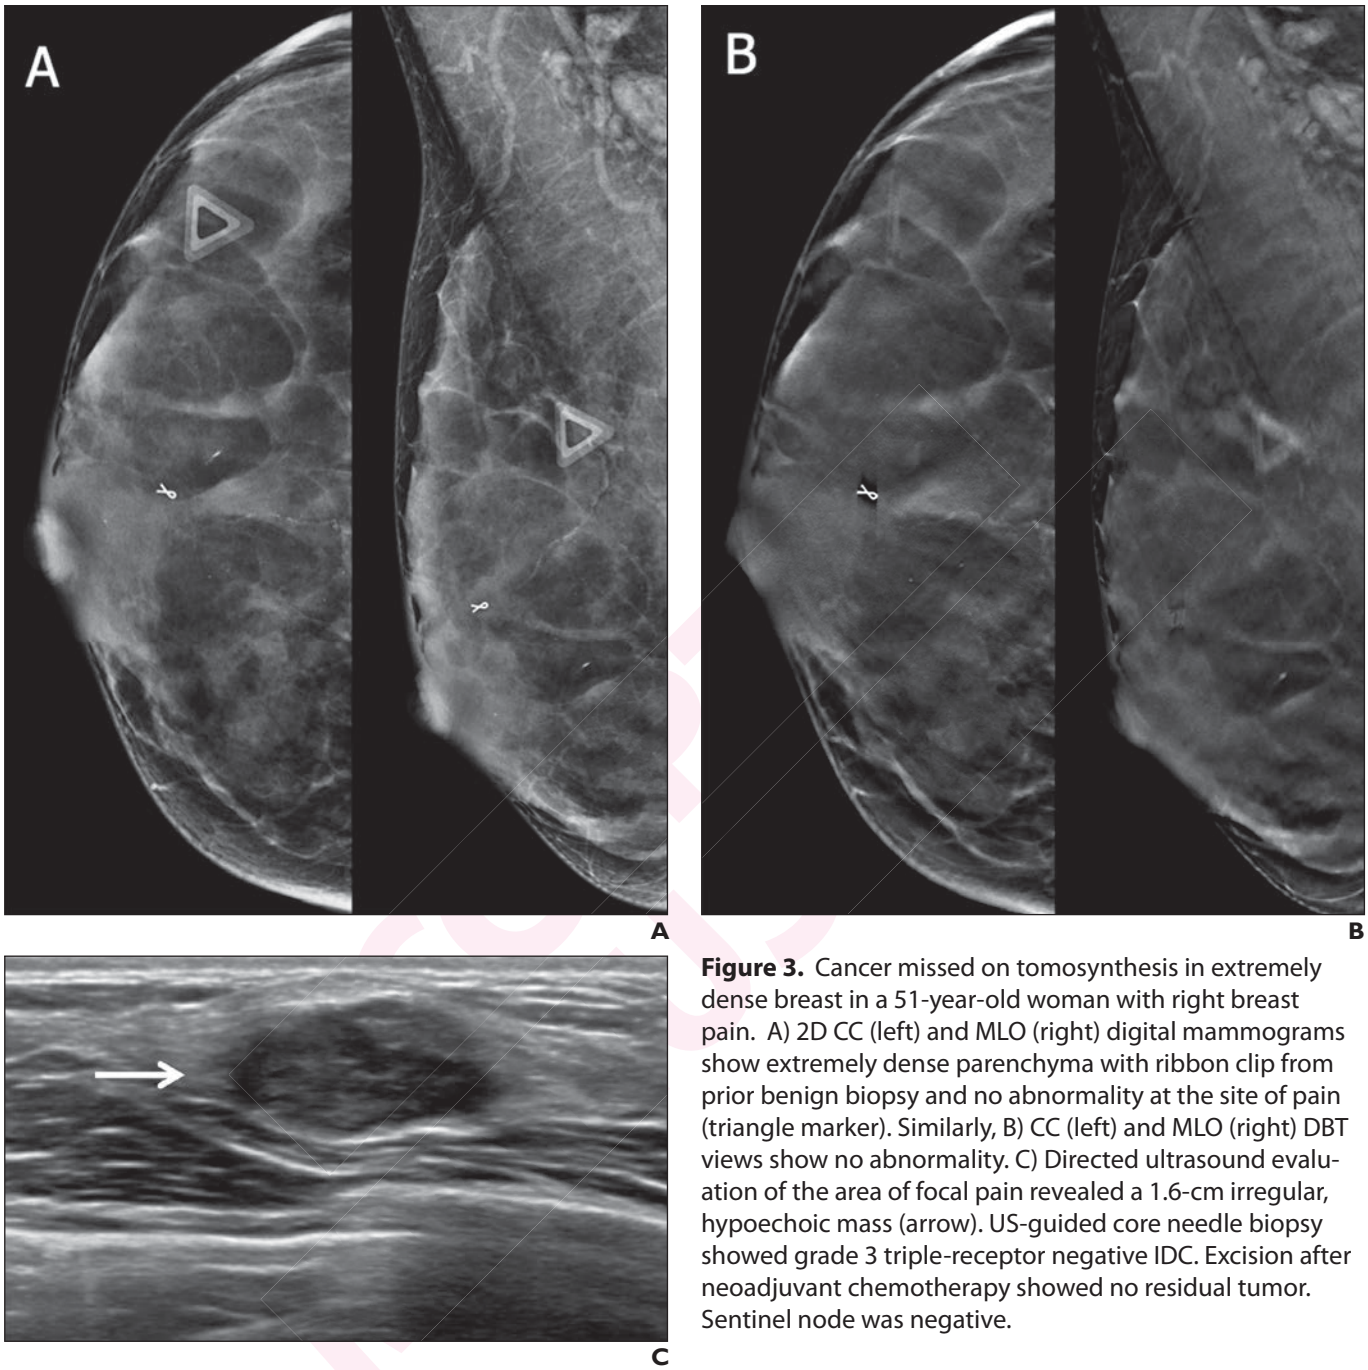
Cancer missed on tomosynthesis in extremely dense breast in a 51-year-old woman with right breast pain. A) 2D CC (left) and MLO (right) digital mammograms show extremely dense parenchyma with ribbon clip from prior benign biopsy and no abnormality at the site of pain (triangle marker). Similarly, B) CC (left) and MLO (right) DBT views show no abnormality. C) Directed ultrasound evaluation of the area of focal pain revealed a 1.6-cm irregular, hypoechoic mass (arrow). US-guided core needle biopsy showed grade 3 triple-receptor negative IDC. Excision after neoadjuvant chemotherapy showed no residual tumor. Sentinel node was negative.
